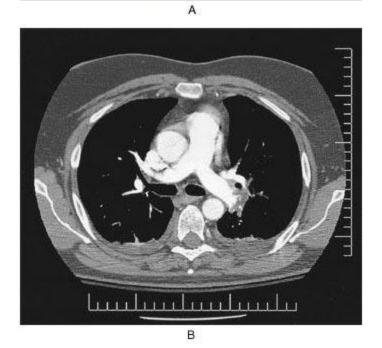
CT pulmonary angiography shows multiple pulmonary emboli in a 63-year-old male with chest pain for 7 days. 2D axial images show presence of thrombus in the main pulmonary arteries with extension to the segmental and subsegmental pulmonary arterial braches on both sides resulting in filling defects (A-C). Coronal reformatted image demonstrates multiple emboli on pulmonary arteries (D). Arrows indicate the thrombi in pulmonary arteries.
